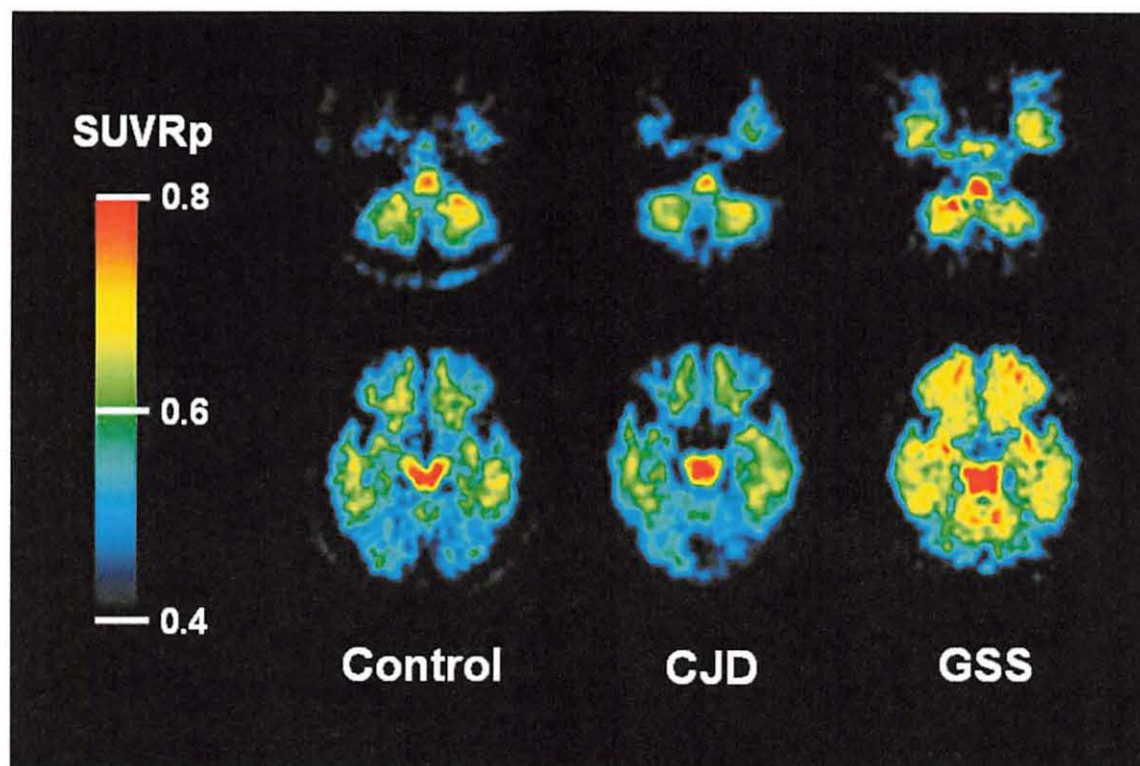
Regional to pons standardized uptake value ratio (SUVR_p) images between 40 and 60 min post injection of [¹¹C]BF-227 in an aged normal subject (64-year-old male), a sporadic CJD patient (63-year-old female), a GSS patient (61-year-old male).
